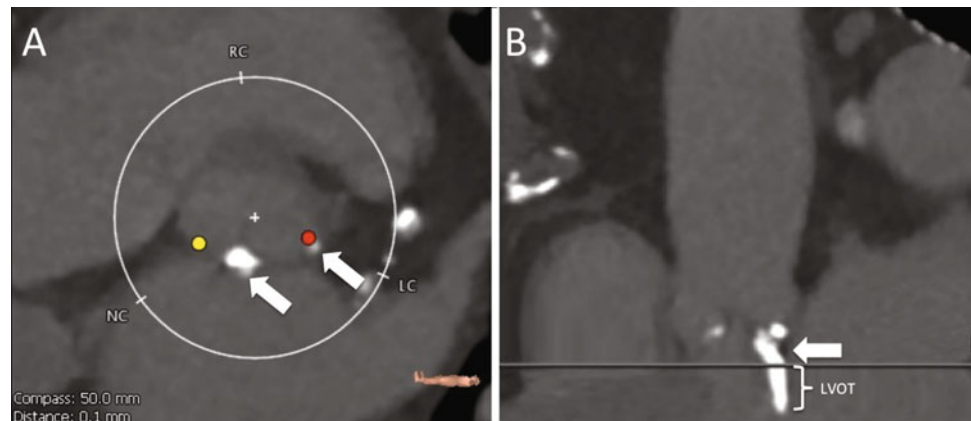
Multidetector cardiac computed tomography revealing severe focal calcification (arrows) of the aortic annulus (a) and left ventricular outflow track (LVOT, b). These calcifications can be related to worse outcomes after surgical or transcatheter aortic valve replacement
